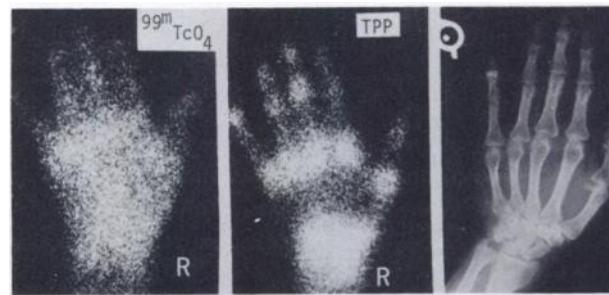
Case 5. Rheumatoid arthritis. Comparison of $^{99m}\text{TcO}_4$, $^{99m}\text{TcPP}$, and x-ray of right hand and wrist. DIP joint changes in roentgenogram are secondary to osteoarthritis.
